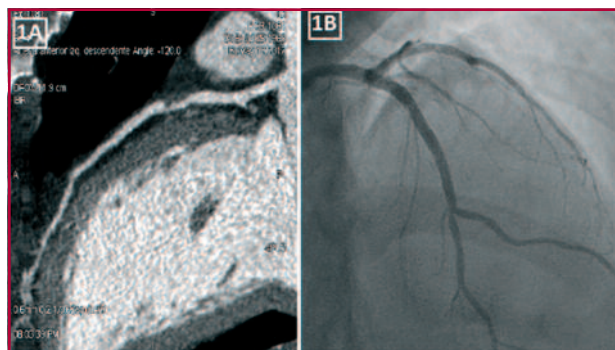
A. Multislice CT-scan image showing 80% obstruction in the proximal third of the anterior descending artery. B. Coronary angiography image showing anterior descending artery with no significant lesions.
